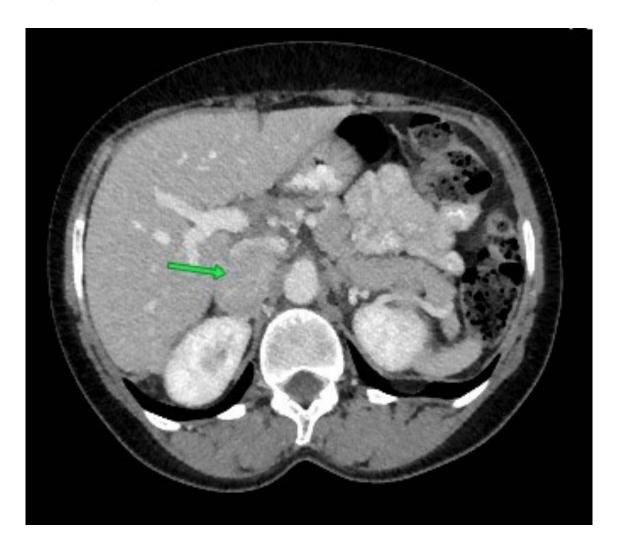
Axial post-contrast CT scan of the abdomen demonstrates a hyper enhancing mass of the right adrenal gland (arrow) displacing the inferior vena cava anteriorly.
